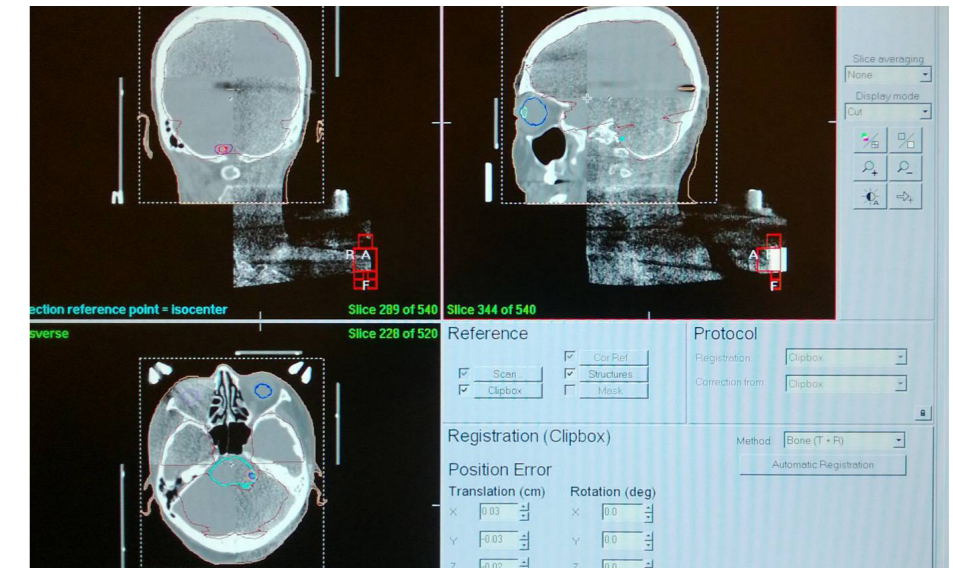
CBCT treatment verification using Elekta XVI
